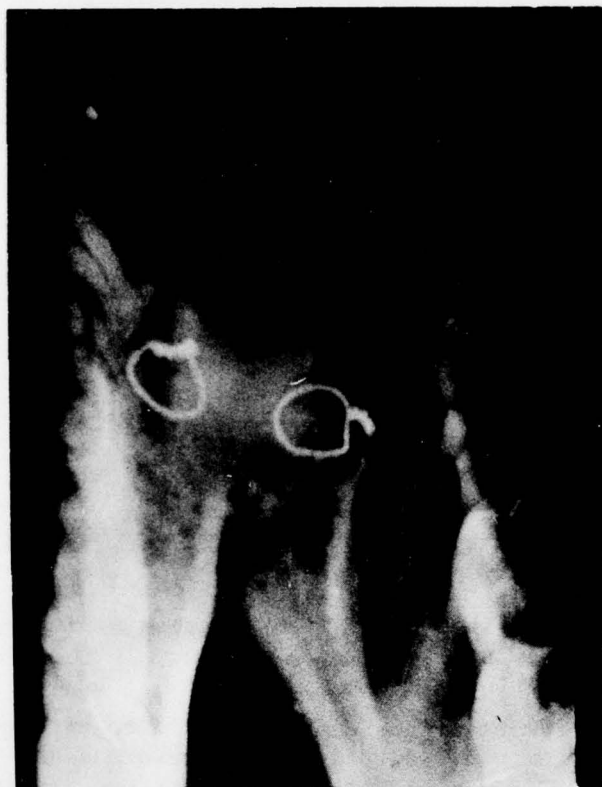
X-radiograph of Bioglass implant in baboon jaw after 3 years (by Clark and Kreuziger).
